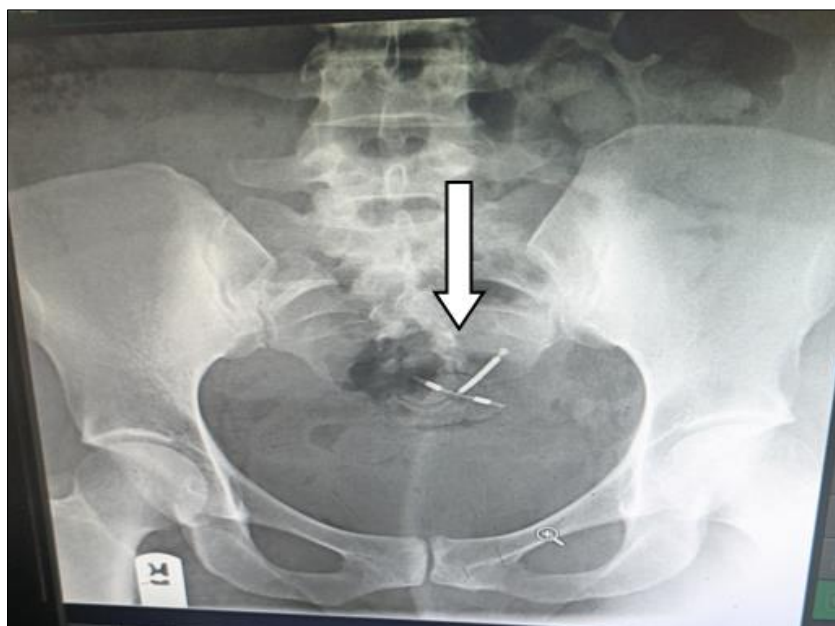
Anterior – Posterior view radiograph of the pelvis showing a ‘Copper T’ IUD projected in the pelvic cavity (arrow)
